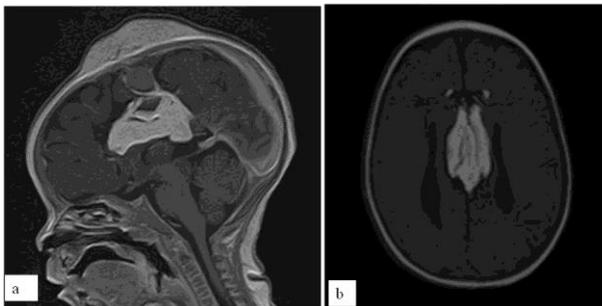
A sagittal (a) and axial (b) T1weighted MRI showing hyperintense frontoparietal subcutaneous and an interhemispheric pericallosal masses.
